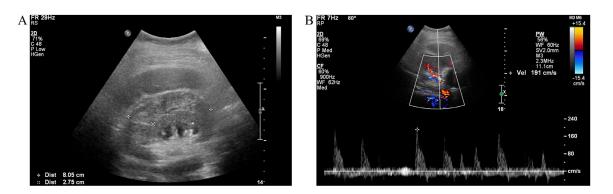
Grayscale (A) and Color/Spectral Doppler images (B) of the right kidney re-demonstrate the large right subcapsular hematoma, with elevated peak systolic velocity and reversed diastolic flow in the main renal artery.
